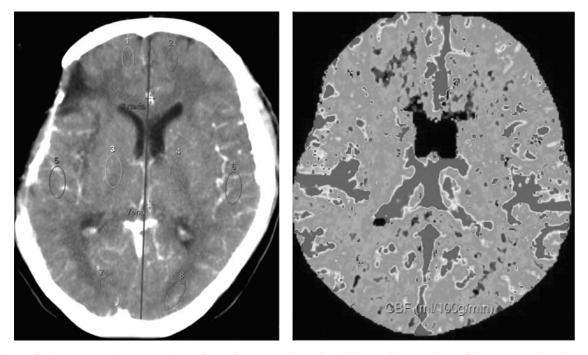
Perfusion computed tomography. Left: a slice centered on the third ventricle. Regions of interest are placed over brain parenchyma perfused by the anterior, middle, and posterior cerebral arteries (ACA, MCA, PCA), and basal ganglia (BG). An artery and vein are selected for software processing. Right: Cerebral brain perfusion map obtained with the partial deconvolution paradigm.
